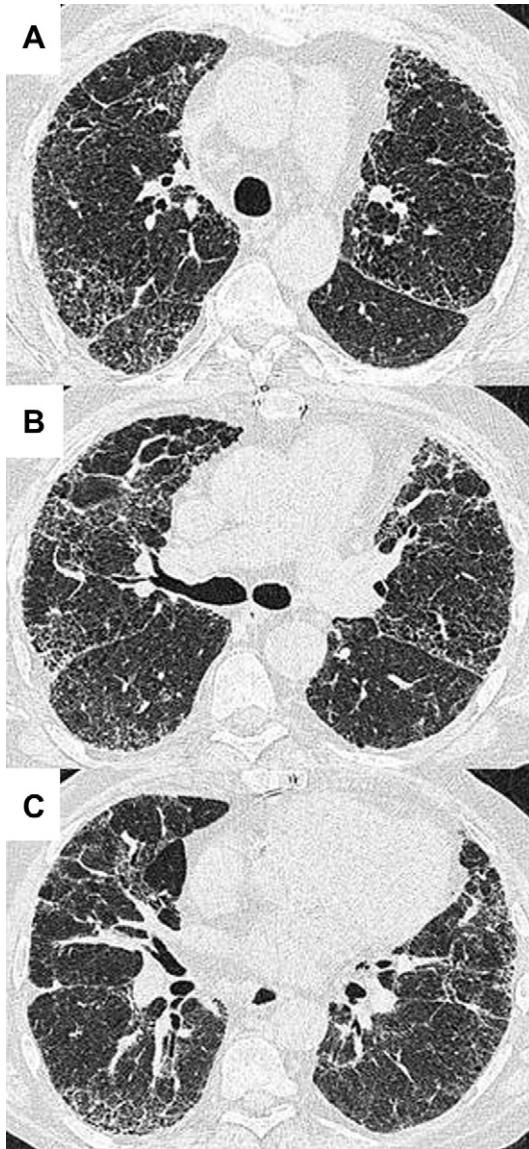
HRCT of a patient with chronic HP showing bilateral reticular shadowing, traction bronchiectasis, and minor mosaic perfusion along with some micronodules. (A) Upper lobes, (B) middle lobes, (C) lower lobes.
